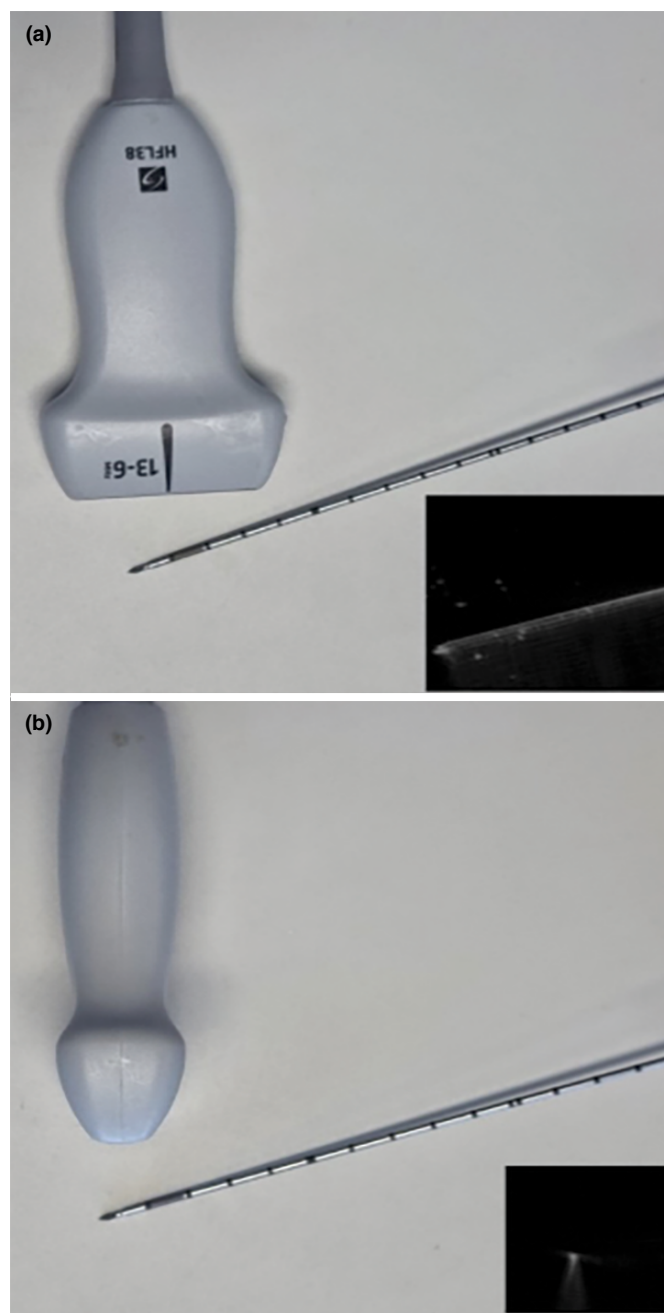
(a) In-plane ultrasound needle guidance. The whole length of the needle can be seen on the ultrasound image. (b) Out-of-plane ultrasound needle guidance. Only the tip of the needle is seen on the ultrasound image
